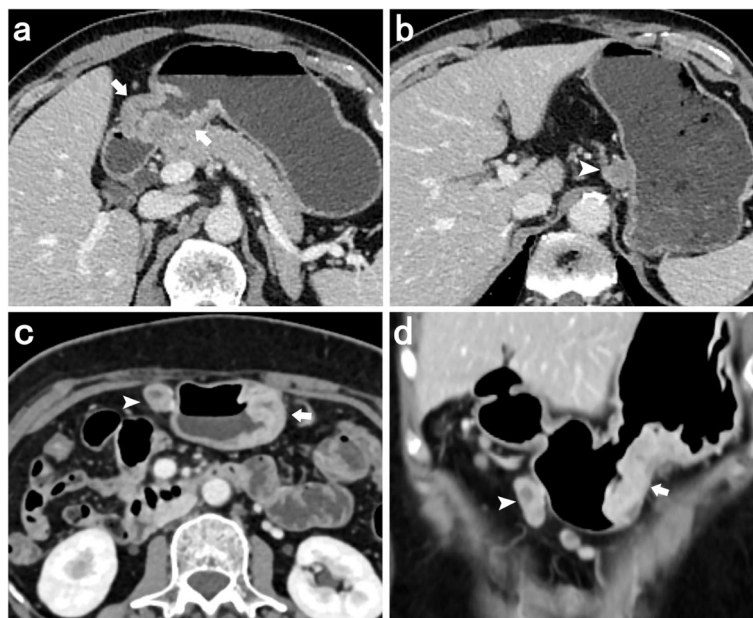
a, b Transverse CT image of a 63-year-old male with gastric antrum cancer (a, arrow). A contrast-enhanced CT image show lymph node metastasis (b, arrowhead) in the stomach lesser curvature with irregular morphology and heterogeneous enhancement. c, d Transverse (c) and coronal (d) CT image of a 56-year-old female with gastric body cancer (arrow). Contrast-enhanced CT image show lymph node metastasis (arrowhead) beneath the gastric antrum with regular morphology and heterogeneous enhancement
